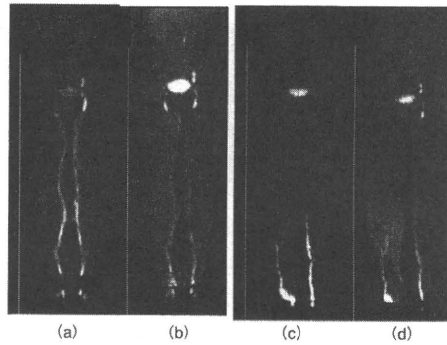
Case 2: lymphoscintigraphic images
